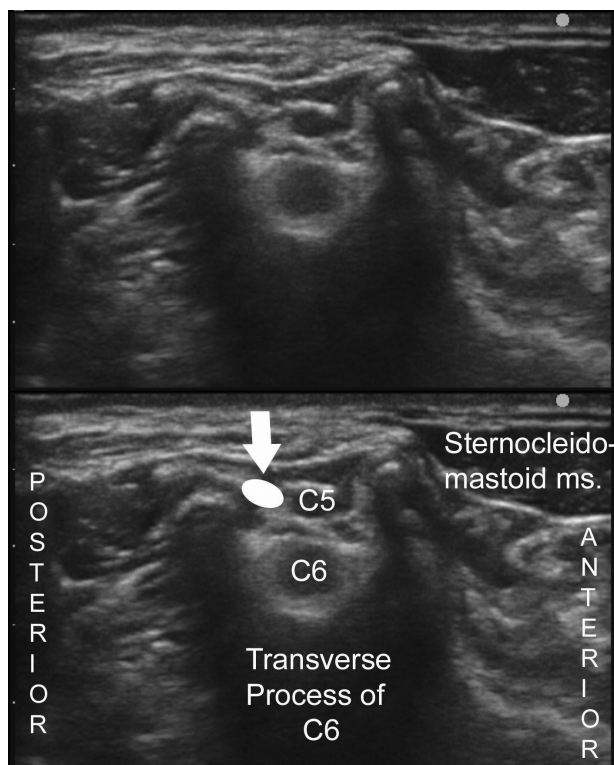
Sonogram showing emergence of a dorsal scapular nerve from C5 nerve root.
